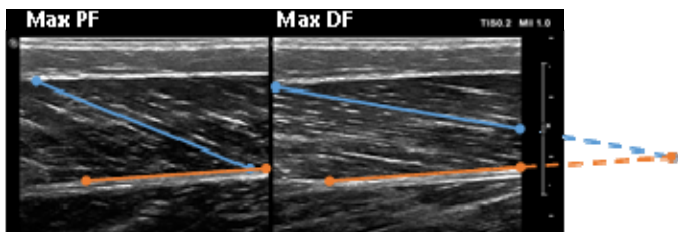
Example of ultrasound images at maximal plantarflexion (PF) and maximal dorsiflexion (DF). Fascicle length was tracked automatically through the full ROM.
